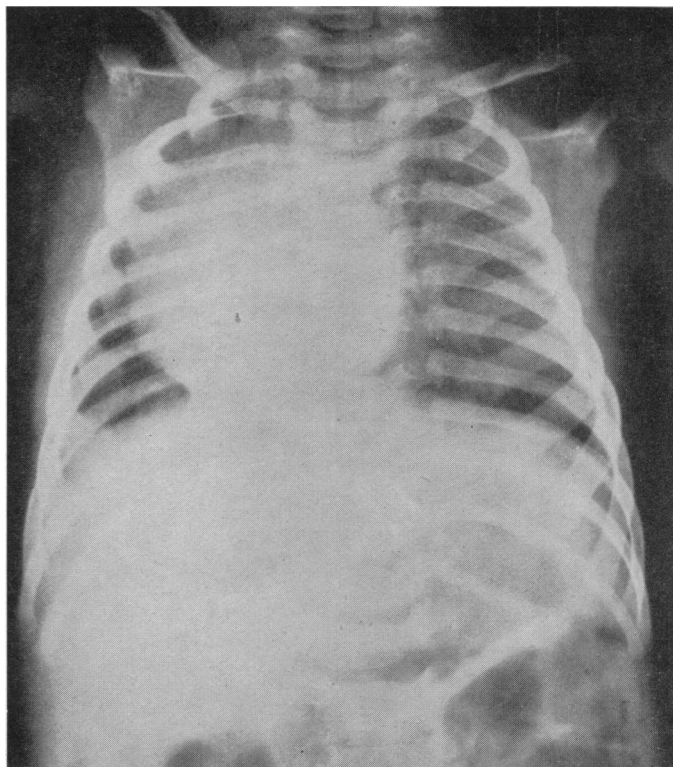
X-ray film of surviving twin showing dextro-rotation of the heart. (Copyright reserved.)
